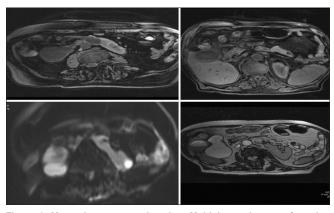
Magnetic resonance imaging: Multiple renal cysts of varying sizes in the cortical as well as medullary regions in a horseshoe kidney
